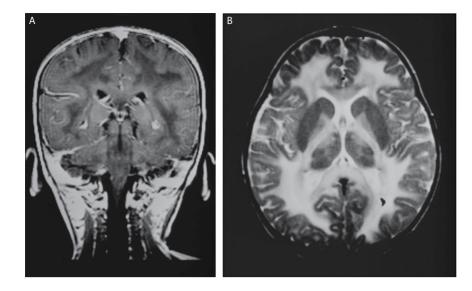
MRI of the brain of the patient in Figure 23.5 at the age of 18 months (A) displaying an extended almost symmetrical demyelinisation of the hemispheric medullary layer involving also the cerebellum; at 24 months (B) there was total demyelinization.
